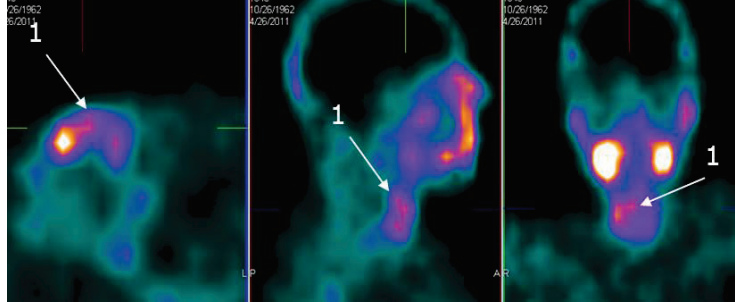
SPECT with ^{99m}Tc -MIBI image of the larynx: laryngeal cancer recurrence following chemoradiotherapy
